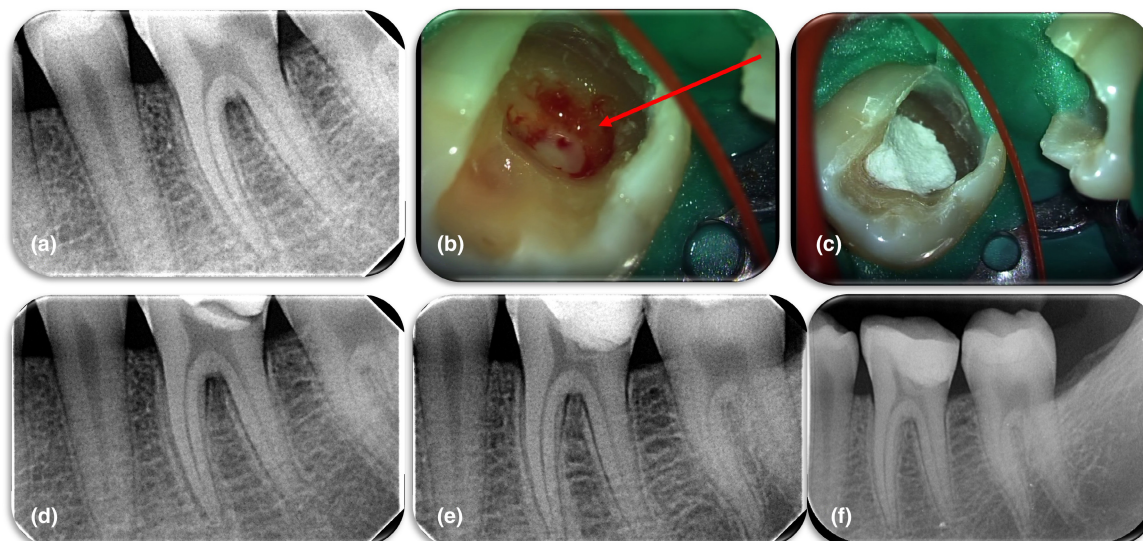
(a) Initial radiograph of a mature first mandibular molar of a 19-year-old patient with periapical lesion in mesial root, the patient take analgesics due to spontaneous pain, the tooth also presents pain to percussion, (b) Pus drainage after communication with pulp chamber during caries removal, (c) placement of MTA Angelus over the remaining coronal pulp tissue, (d) postoperative radiograph of the case, (e) 6-month recall radiograph. Formation of dentinal bridge is apparent, note however, the inadequate margins of permanent coronal restoration (f) 36-month recall radiograph. The inadequate restoration has been replaced with a new sufficient restoration. No lesions are present and complete periapical healing has occurred, a thick dentinal bridge has been completely developed.
